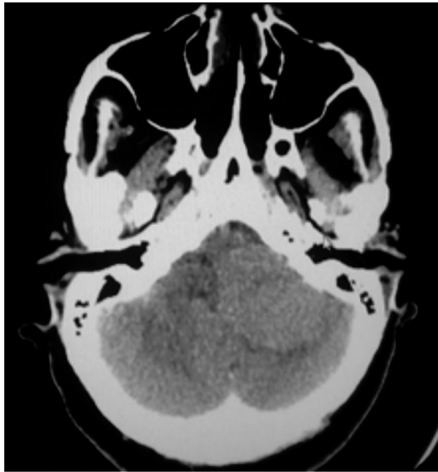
Preoperative CT scan - large tumor of the left cerebellopontile angle
